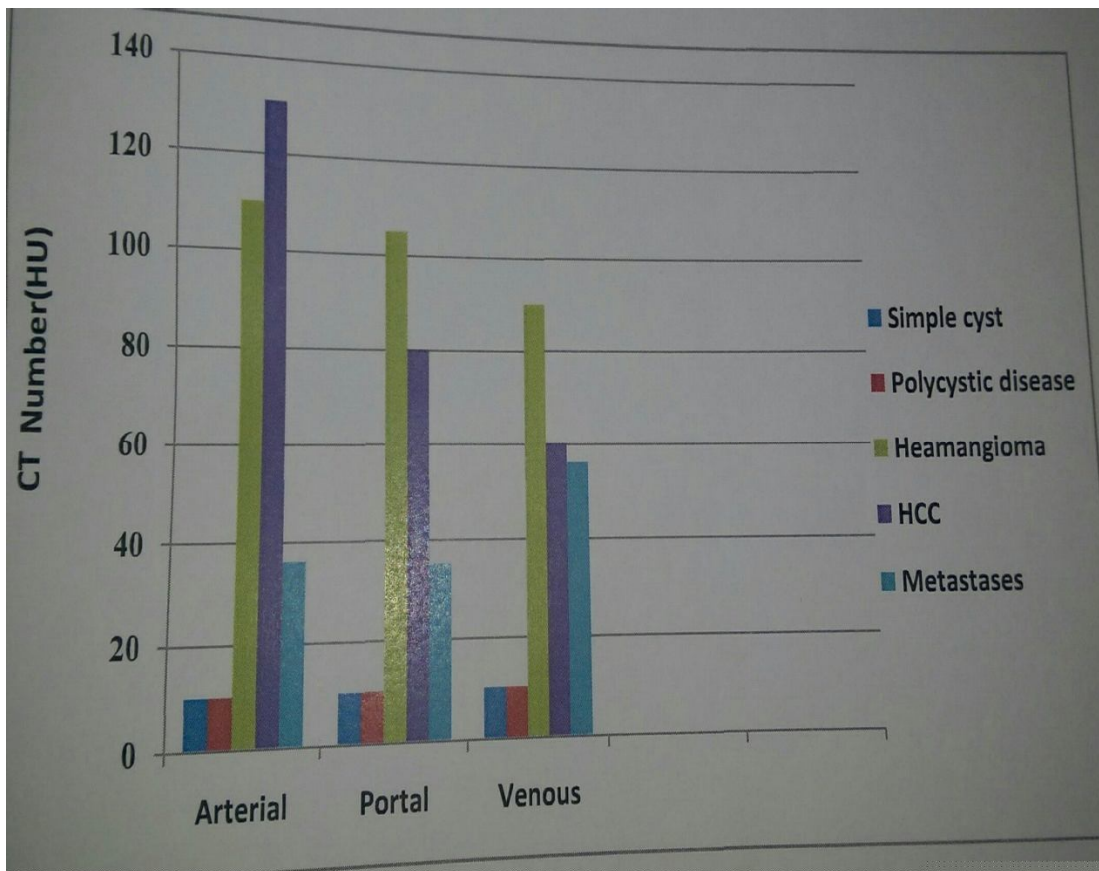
shows the degree of enhancement of the liver lesion by CT Number (HU)
